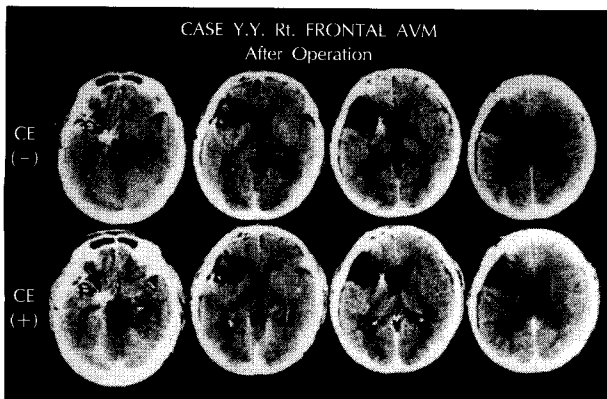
Head CT scan after removal of AVM of the case 1 revealed surgical defect and clips located at right frontal.
